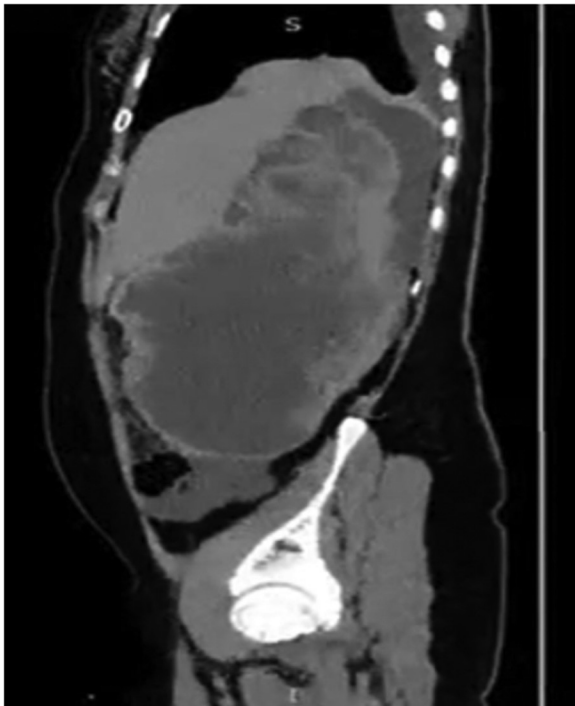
Repeat CT scan imaging revealed a 24cm x 13cm x 15cm mass displacing the liver anteriorly.
